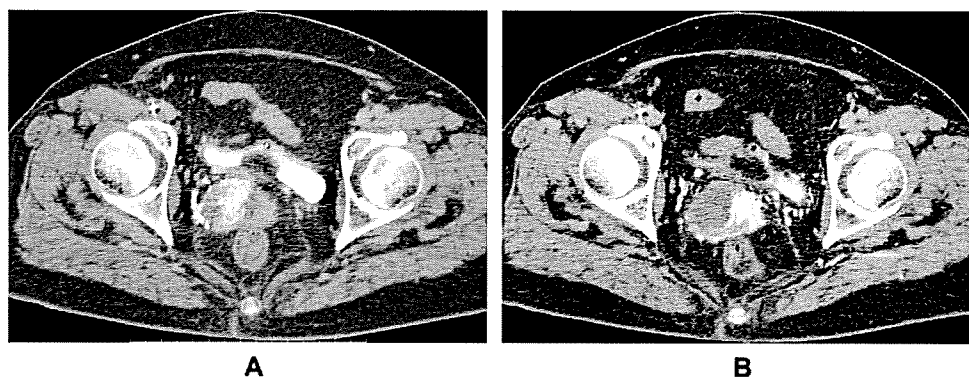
Computed tomography during pelvic arteriography. Bilateral uterine arteriography before the first infusion. (A) Infusion from right uterine artery. (B) Infusion from left uterine artery. In the case in which the tumor is enhanced by the area, the proportion of cisplatin dose would be 4 to 1 for right to left. The dose of cisplatin was determined according to findings of pelvic examination CT/MRI, and CTPA. The enhanced area on the right is larger than on the left.
